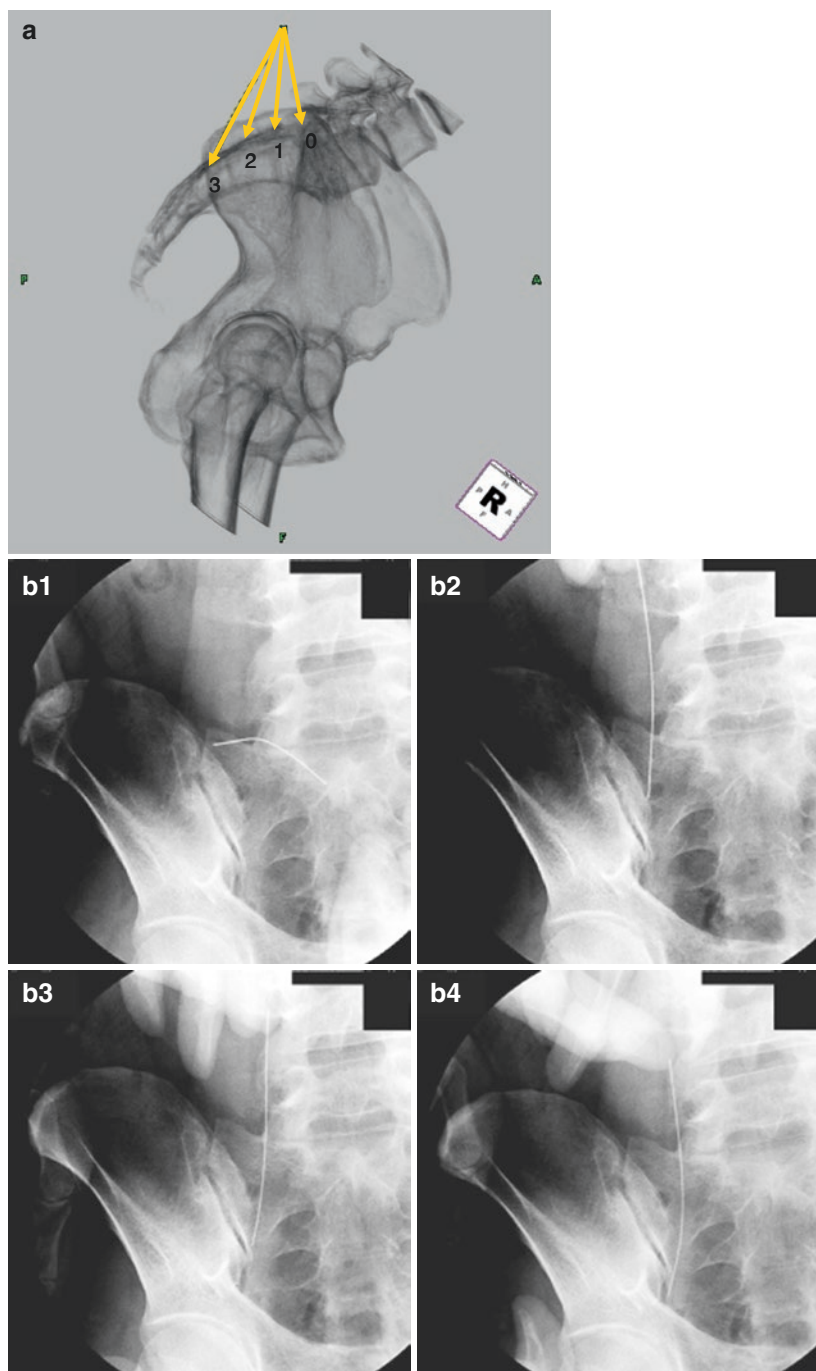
(a) A needle insertion into the four sections (0–3) may be possible by adjusting the direction of the needle skillfully. (b) X-ray of a needle insertion into the four sections (0–3). (b-1, Area 0; b-2, Area 1; b-3, Area 2; b-4, Area 3) With permission from [7]
